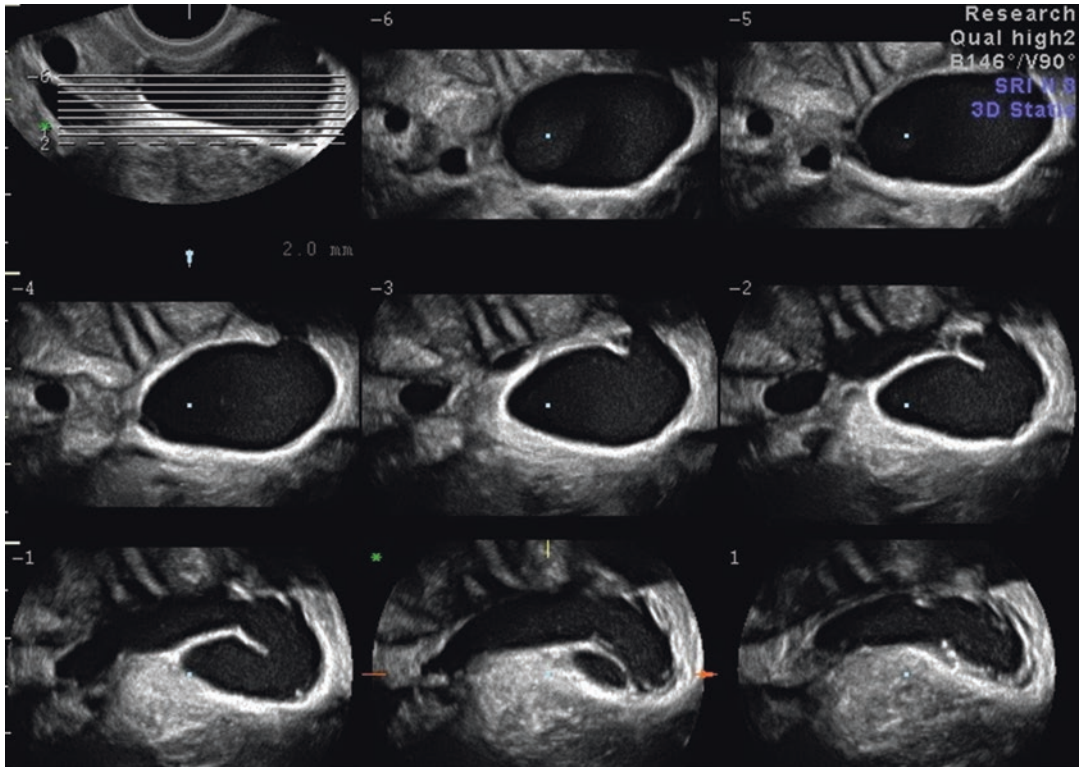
3D TUI (tomographic ultrasound imaging) of hydrosalpinges with views at different depths within the hydrosalpinges
